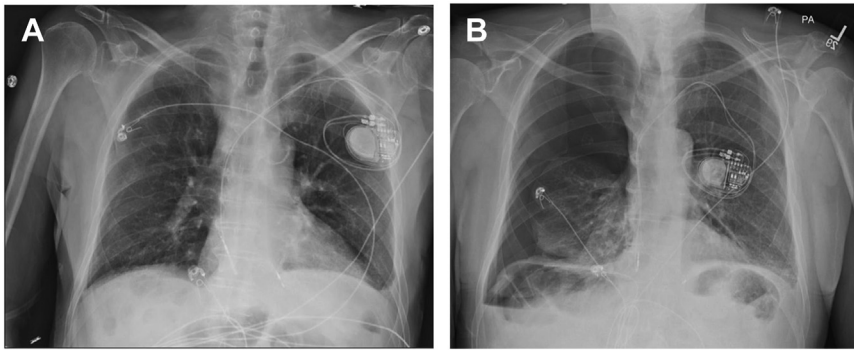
Chest radiography in anteroposterior (left) view. A: Image at device implantation conclusion, without hemopneumothorax. B: Image at 24 hours postprocedure, with large contralateral right-sided pneumothorax with lung collapse. Note there is no translocation observed in either right atrium or right ventricle lead position from time of implant.
